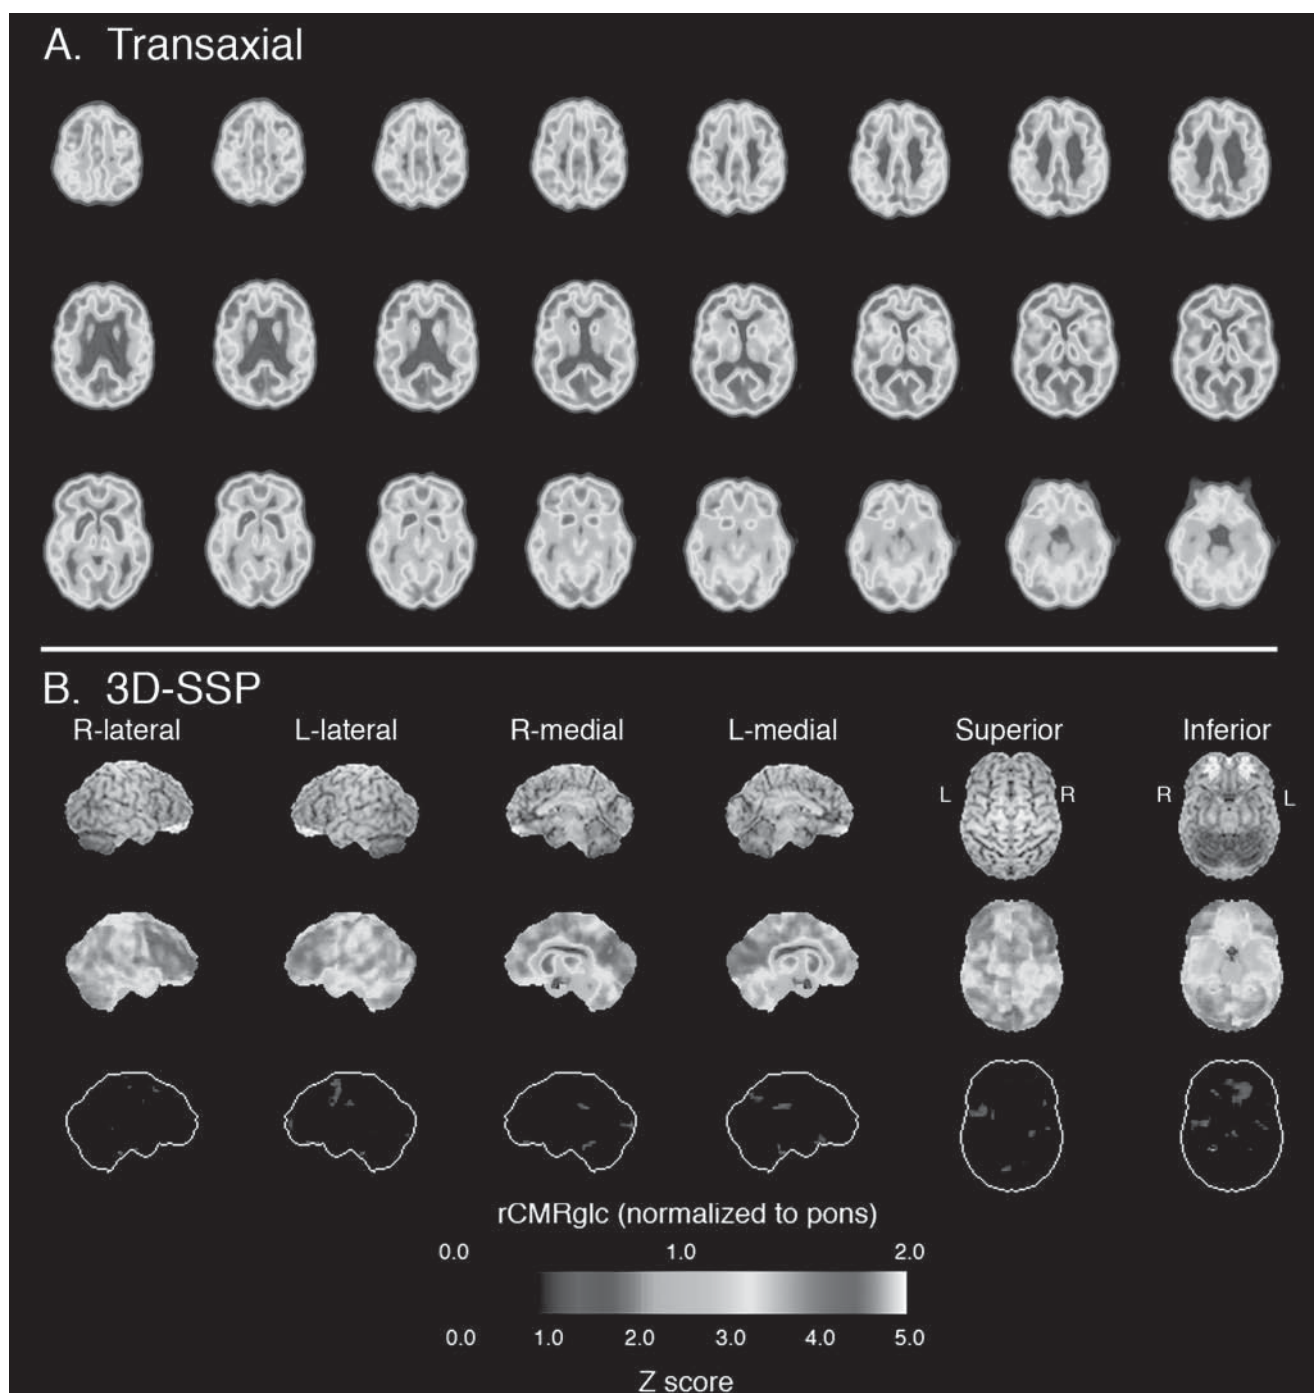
Fluorodeoxyglucose positron emission tomography (FDG-PET) image in a cognitively normal elderly individual. (See color plate 1)
